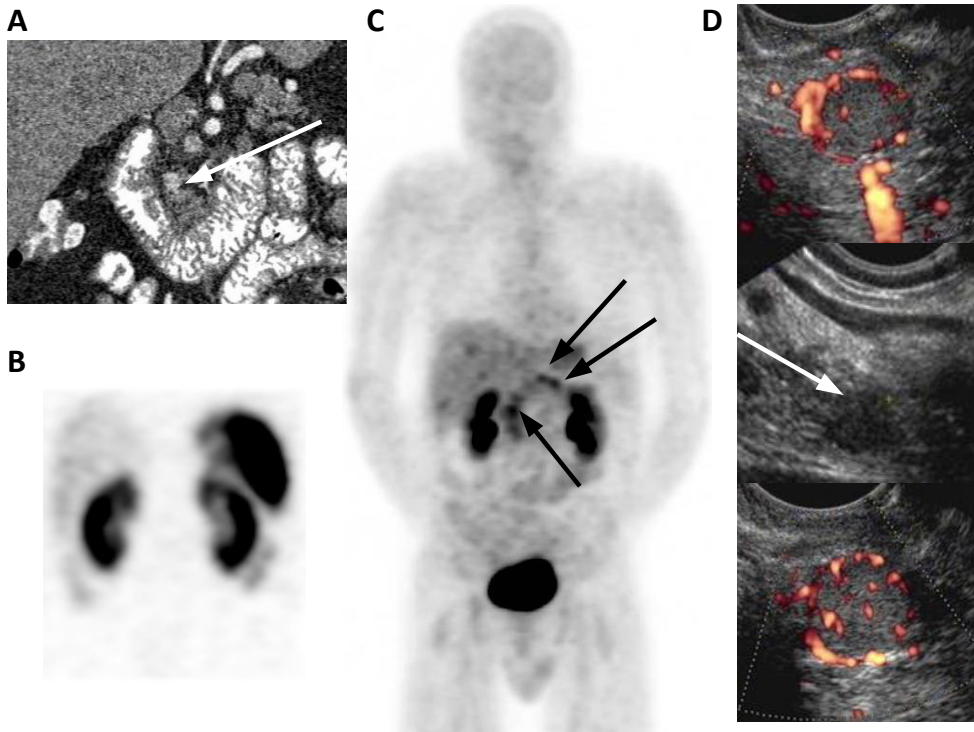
A Coronal images of CT scan, B SRS SPECT image, C maximum intensity projection image of ^{11}C -5-HTP PET and D ultrasound images of pancreatic lesions visualized with EUS. In total 4 pancreatic solid lesions were detected. With CT, 1 lesion was found. The SRS was negative. ^{11}C -5-HTP PET detected 3 lesions: 1 in the pancreatic head and 2 in the body-tail region. EUS detected 2 hypoechoic solid lesions in the pancreatic head and 1 in the body-tail region ranging 9.7-14.1 mm. Two solid lesions showed hypervascularity with power Doppler.
